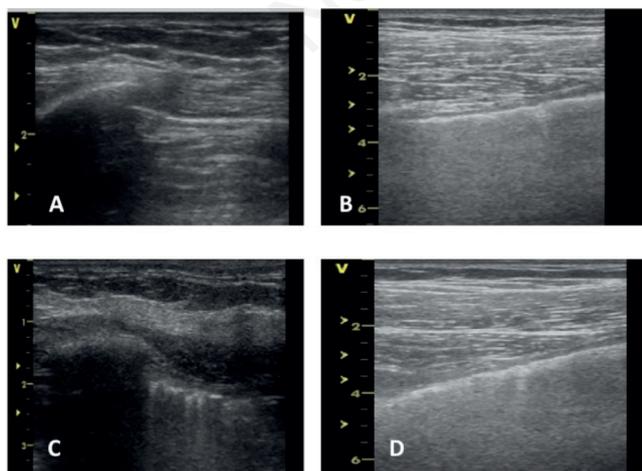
Main chest ultrasound pleural findings. A) Normal pleural line. B) Irregular pleural line. C) Fragmented pleural line. D) Blurred pleural line.
